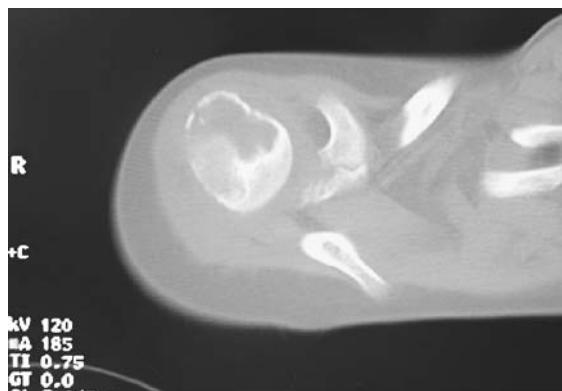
Axial CT image of the right shoulder better delineates the well-defined purely lytic lesion in the anterior and lateral aspects of the proximal humeral epiphysis, with no matrix calcification, marginal sclerosis, periosteal reaction or soft-tissue mass
